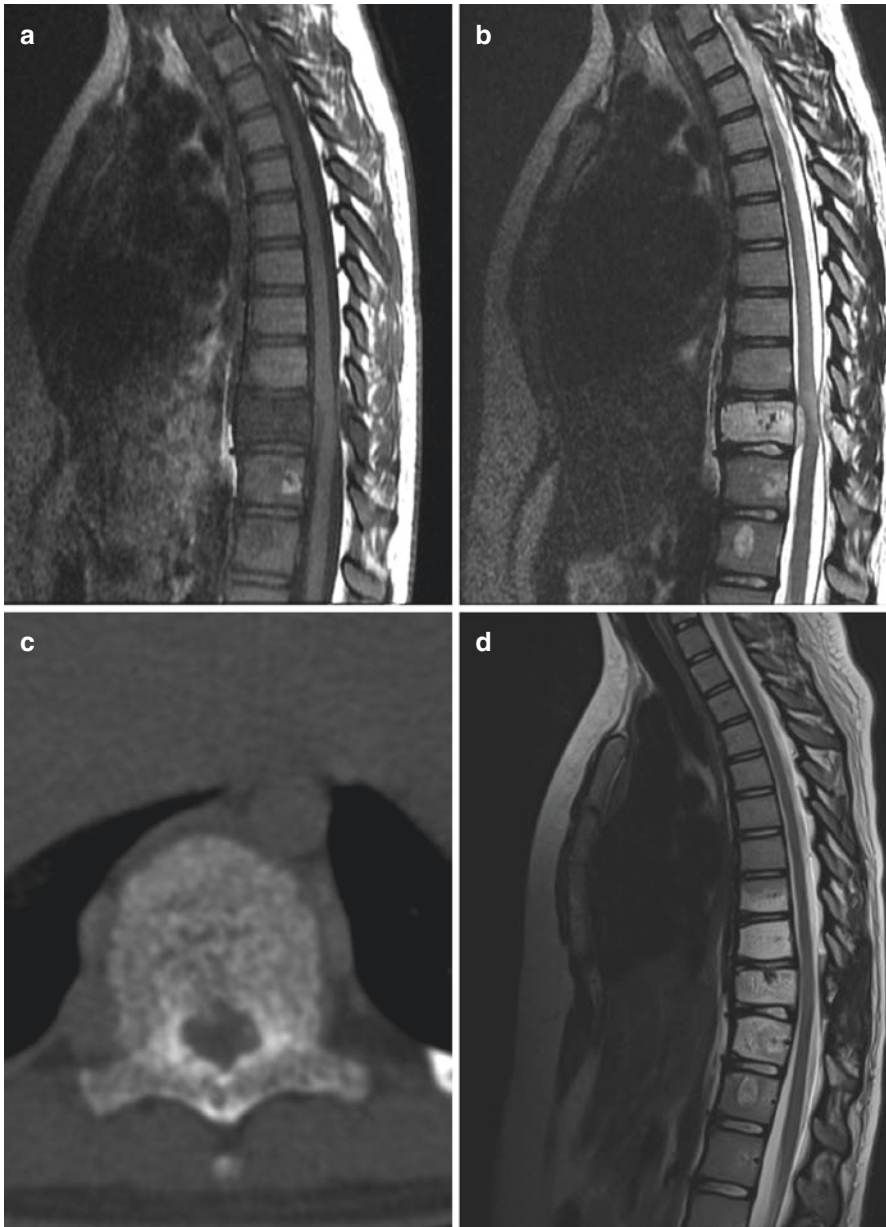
MRI and computed tomography pictures of a 9-year-old patient with symptomatic thoracic vertebral hemangioma managed with radiotherapy. (a) T1-weighted image of the vertebral hemangioma. (b) T2-weighted image of the lesion with significant anterior and posterior cord compression. (c) Axial CT image of the lesion. (d) Post-radiotherapy image 3 months after the treatment showing complete resolution of the extraosseous lesions and the cord compression
